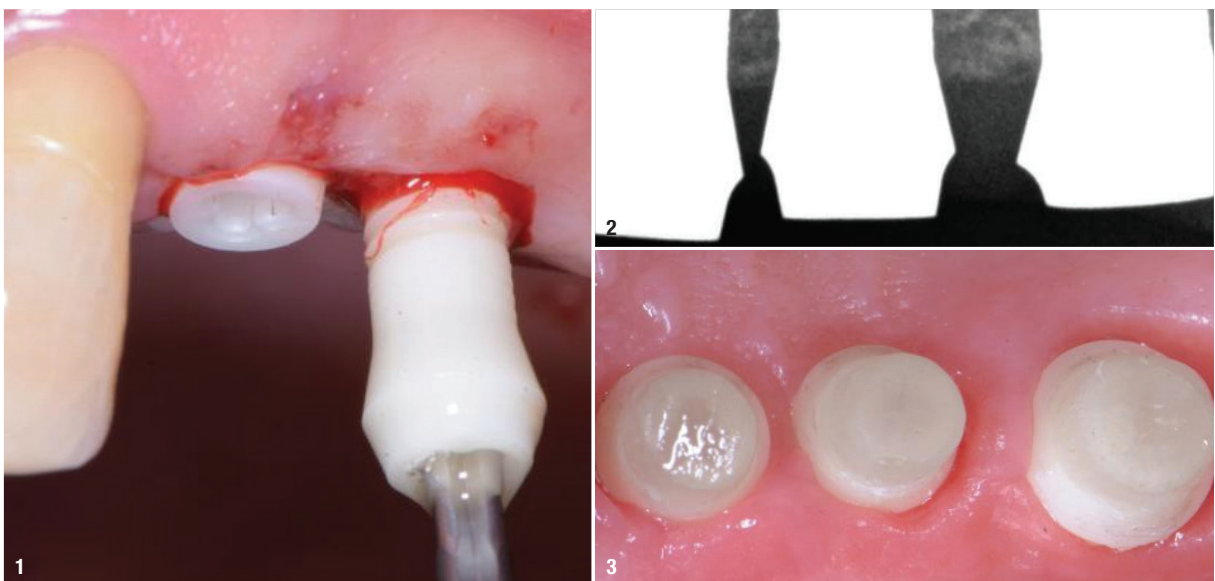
Implant insertion. The Patent™ implant has a hydrophilic surface. Fig. 2: Control radiograph at the time of surgery. Fig. 3: Glass fibre posts cemented and prepared after a healing period of three months. Note the healthy soft tissues.
